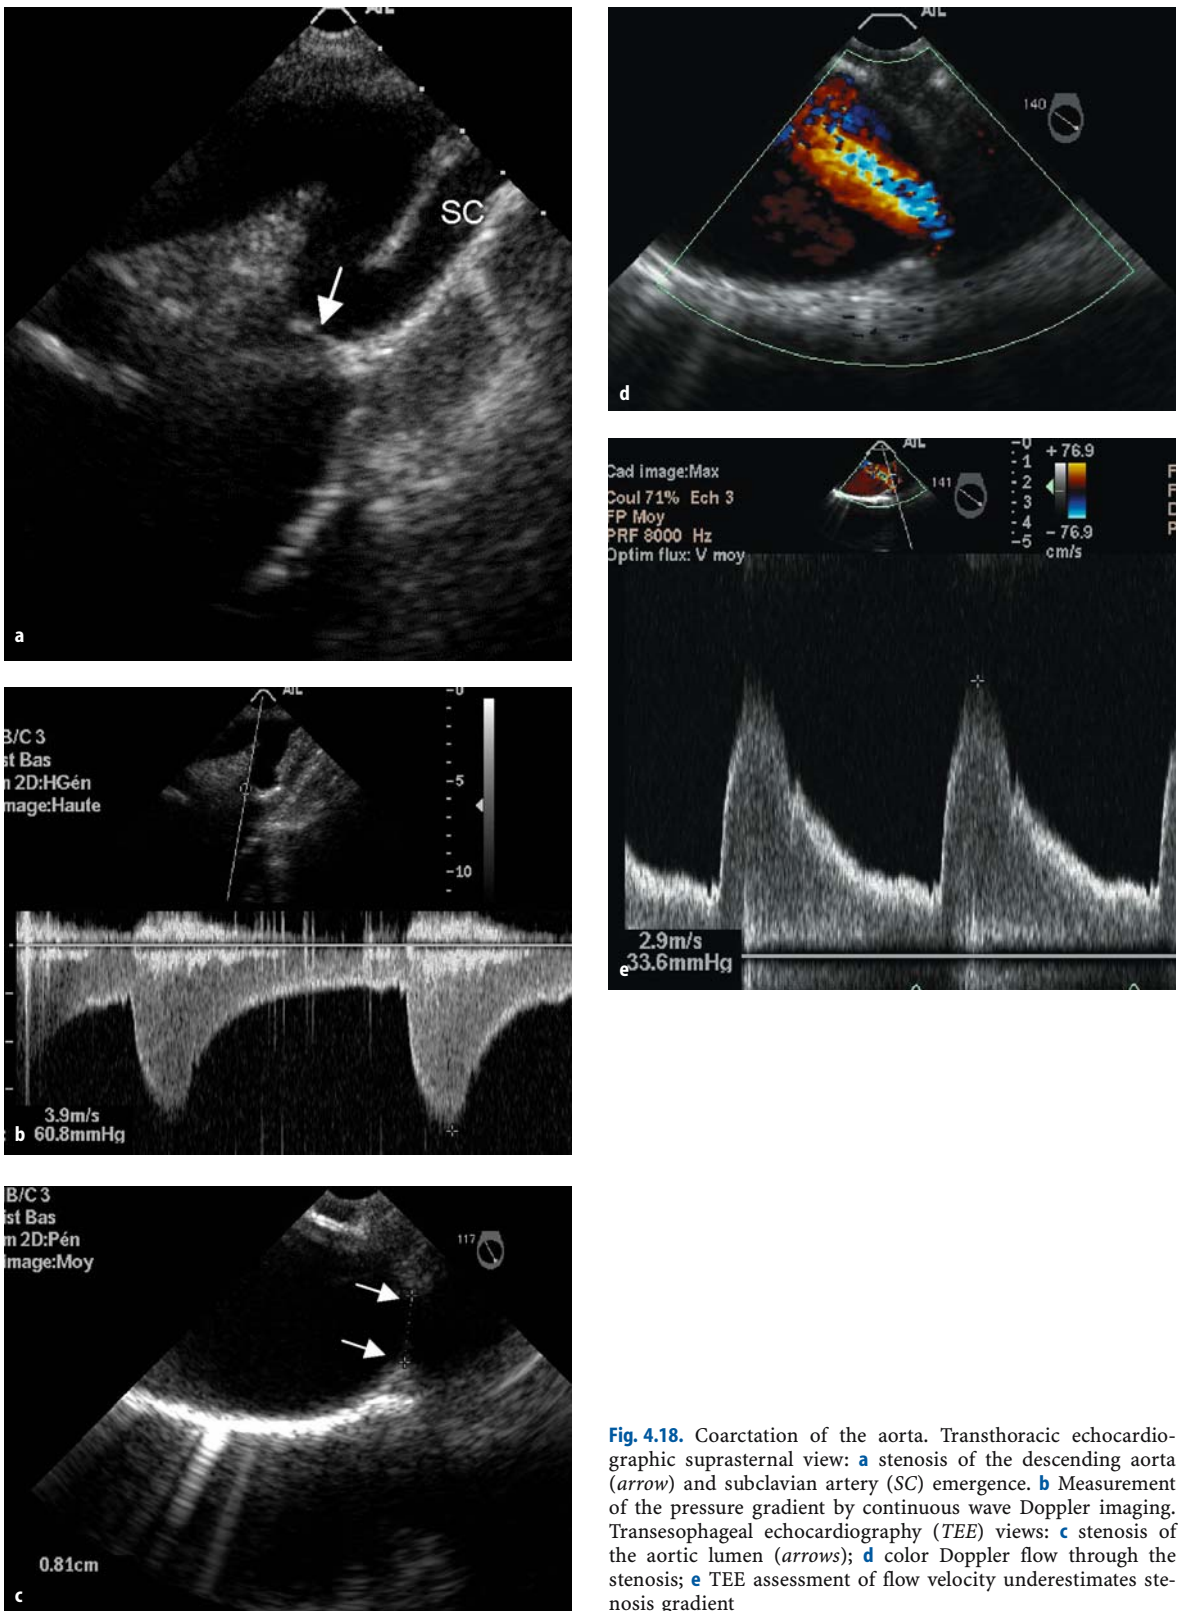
Coarctation of the aorta. Transthoracic echocardiographic suprasternal view: a stenosis of the descending aorta (arrow) and subclavian artery (SC) emergence. b Measurement of the pressure gradient by continuous wave Doppler imaging. Transesophageal echocardiography (TEE) views: c stenosis of the aortic lumen (arrows); d color Doppler flow through the stenosis; e TEE assessment of flow velocity underestimates stenosis gradient
